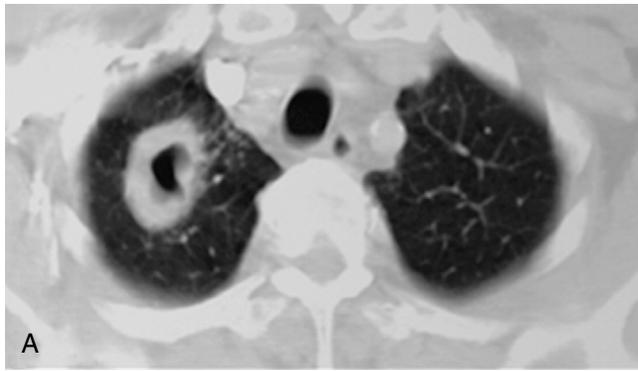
Fungus ball in mycobacteria-induced lung cavity. (A) Radiograph showing a thick-walled cavity. (B) Radiograph performed 1 year later showed a thin-walled cavity with a dependent mass. (C) Fine needle aspiration contained hyphae morphologically consistent with *Aspergillus* spp. (GMS).
